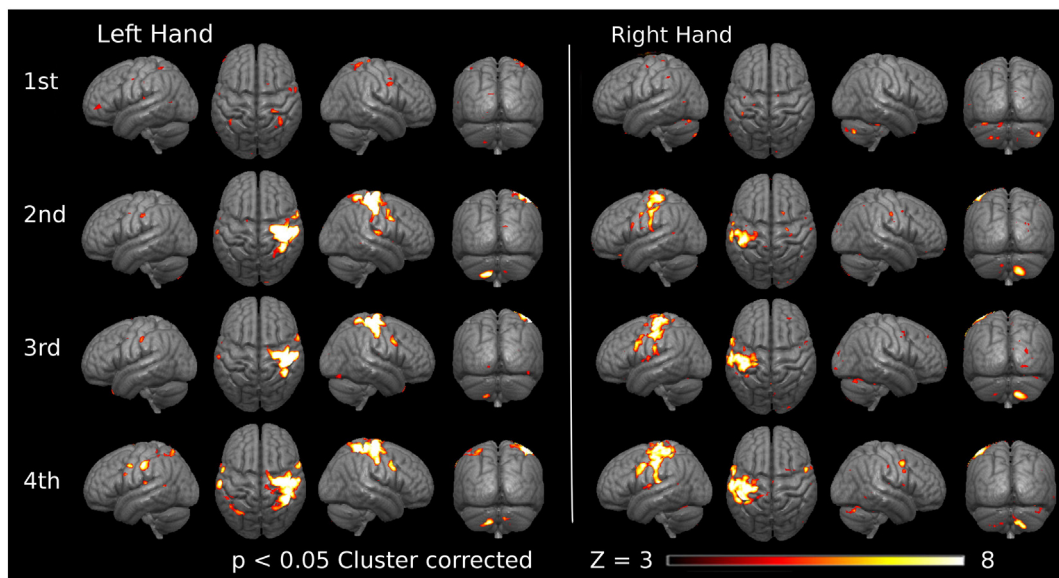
Cortical activation during sensory stimulation of the transplanted hands. Rows indicate the time point of MRI acquisition across four consecutive years. In the top and posterior views the right hemisphere is represented on the right.
